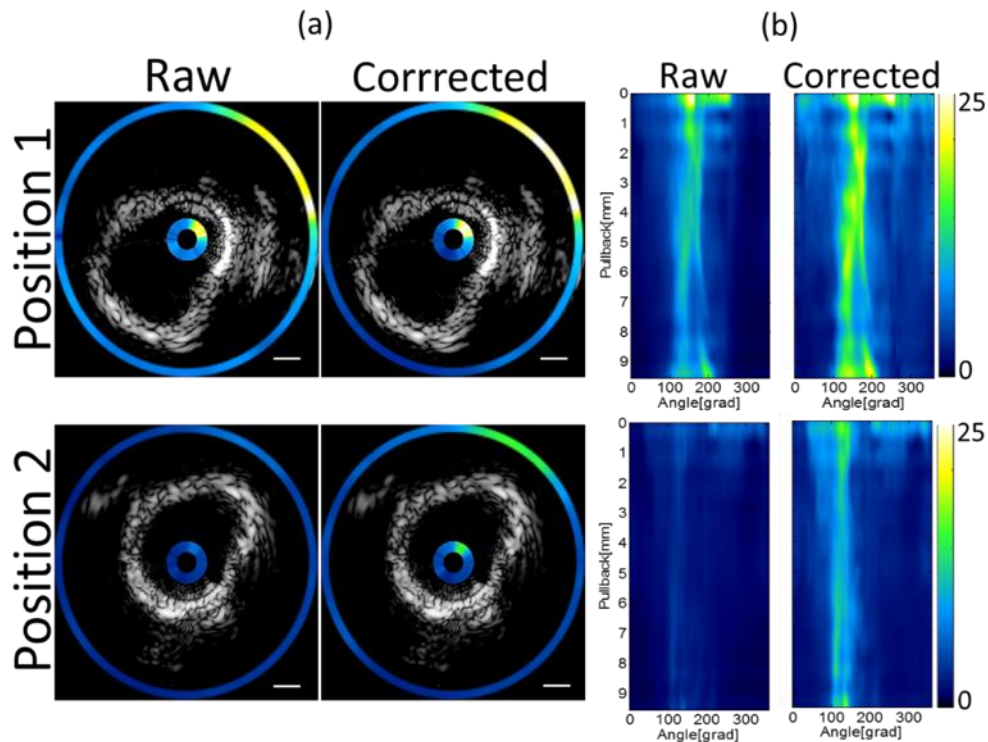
Results of ex vivo measurements in abdominal rabbit aorta with AF750 injected into the vessel wall after significant repositioning of the catheter. (a) Two imaging sessions of the same region of the vessel were performed with catheter placed in different intraluminal positions: top right (Position 1) and bottom-center (Position 2). Representative examples of the ultrasound images obtained from different positions are presented in black and white colors. Colored circular rings represent corresponding NIRF signal, and are depicted on the interior of the IVUS catheter, as well as externally around the vessel wall. (b) Raw and corrected NIRF images obtained over whole pullback in Position 1 and Position 2, respectively. All scale bars 1mm.
